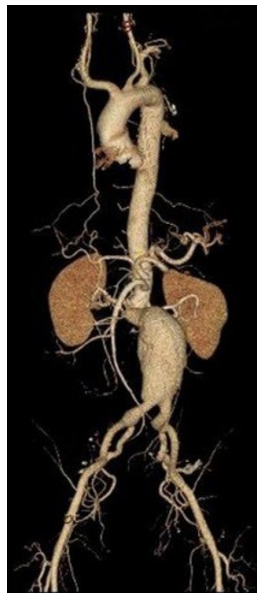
Volume rendered CT angiogram of an abdominal aortic aneurysm (Website 1).
